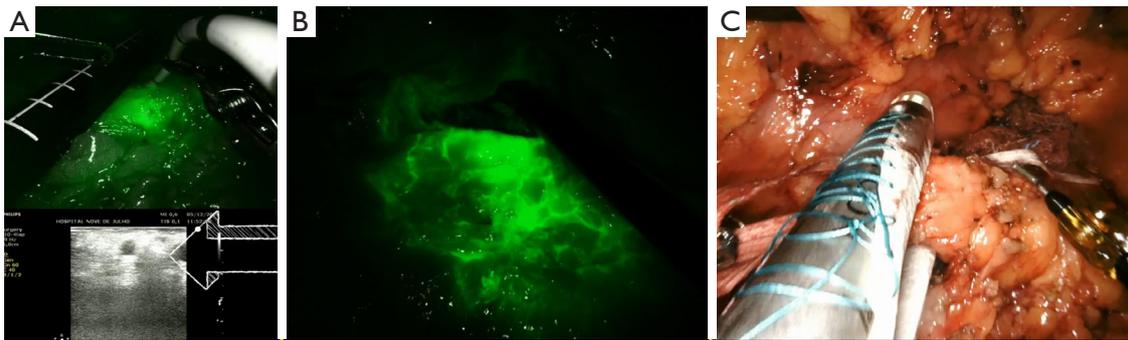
Intraoperative images. (A) Injection of ICG in the pancreas close to the tumor with robotic fluorescence and ultrasonography guidance using picture-in-picture mode; (B) fluorescence enhancement of the mesocolon disclosing lymphatic drainage of the pancreas; (C) transection of the pancreatic body with an endoscopic vascular stapler. ICG, indocyanine green.
